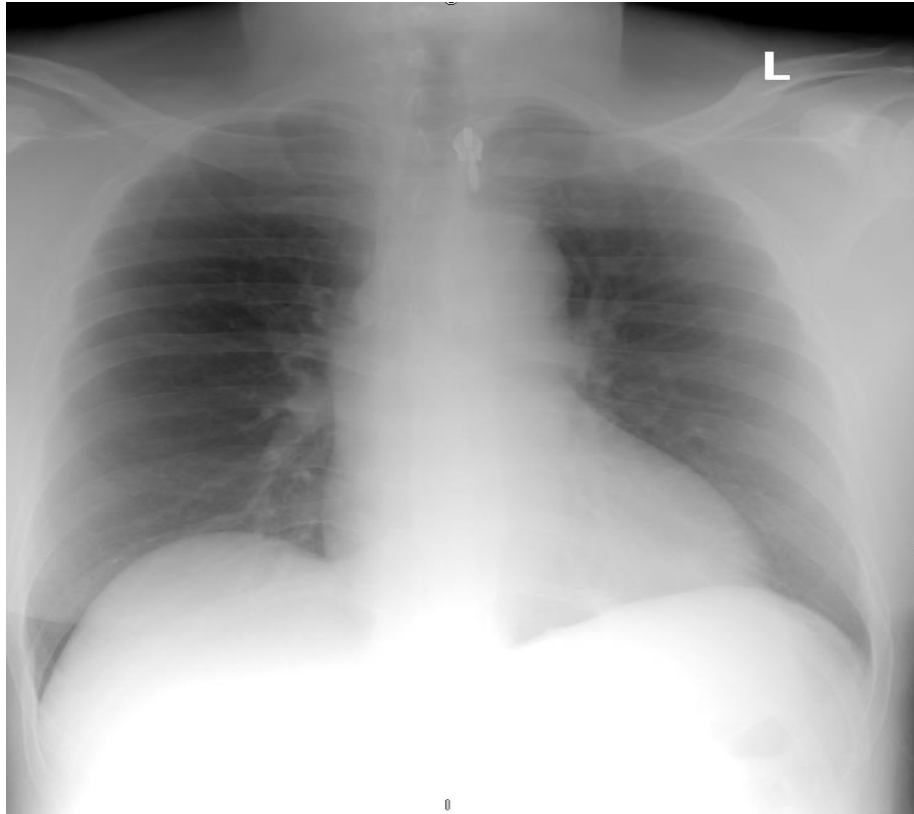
Chest X-ray revealing a widened mediastinum, a characteristic radiographic sign of acute aortic dissection
